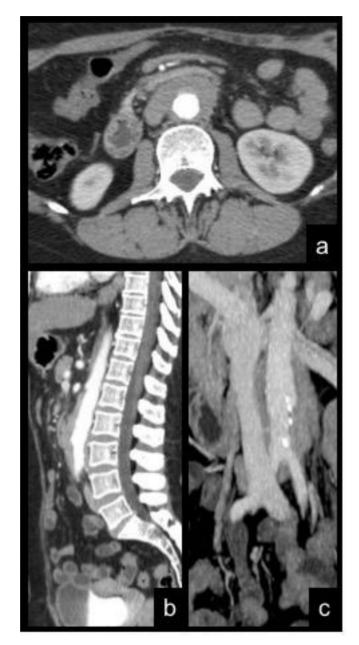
CT without contrast media CB, male, 90 yo, Abdominal aortitis due to retroperitoneal fibrosis
